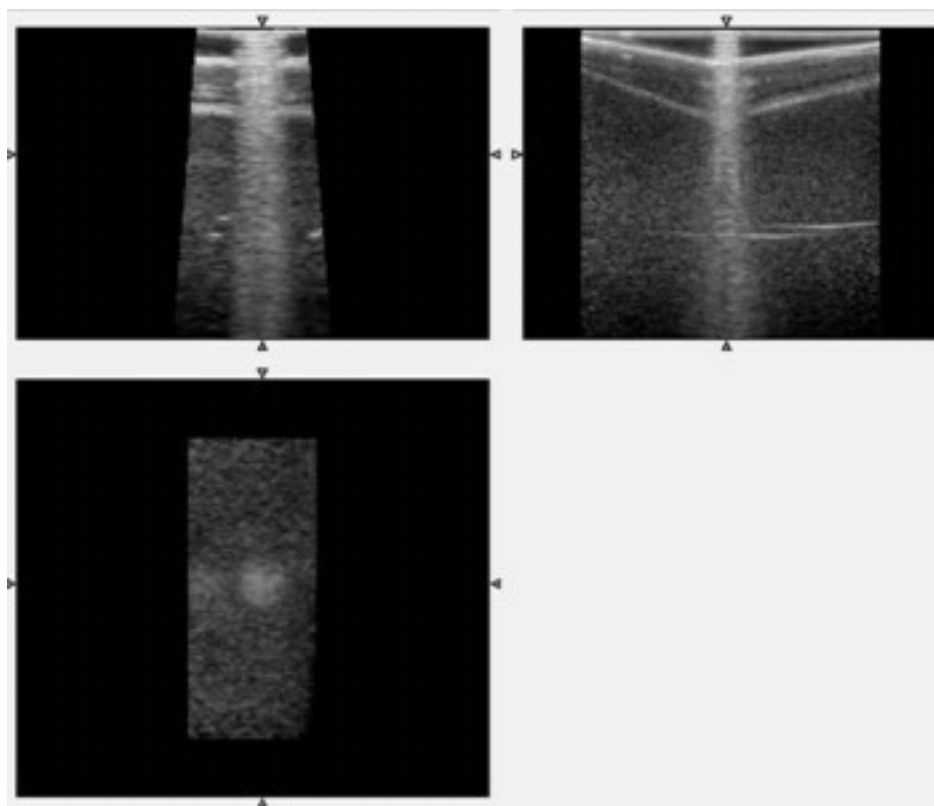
Influence of a fiducial marker placed in front of the cone window on the ultrasound image quality
